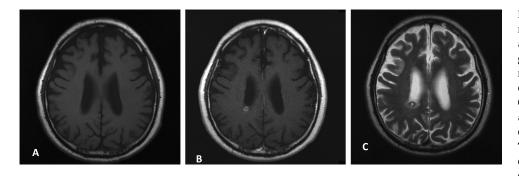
Axial T_1 -weighted magnetic resonance images at 28 months after onset without (A) and with (B) gadolinium injection demonstrating new ring-shaped enhancing lesion on the wall of right lateral ventricle. C: T_2 -weighted image show a lesion at the same portion of ring-shaped enhancement surrounded by edema. The relatively wide expansion of edema compared with the lesion suggest metastatic tumor.
